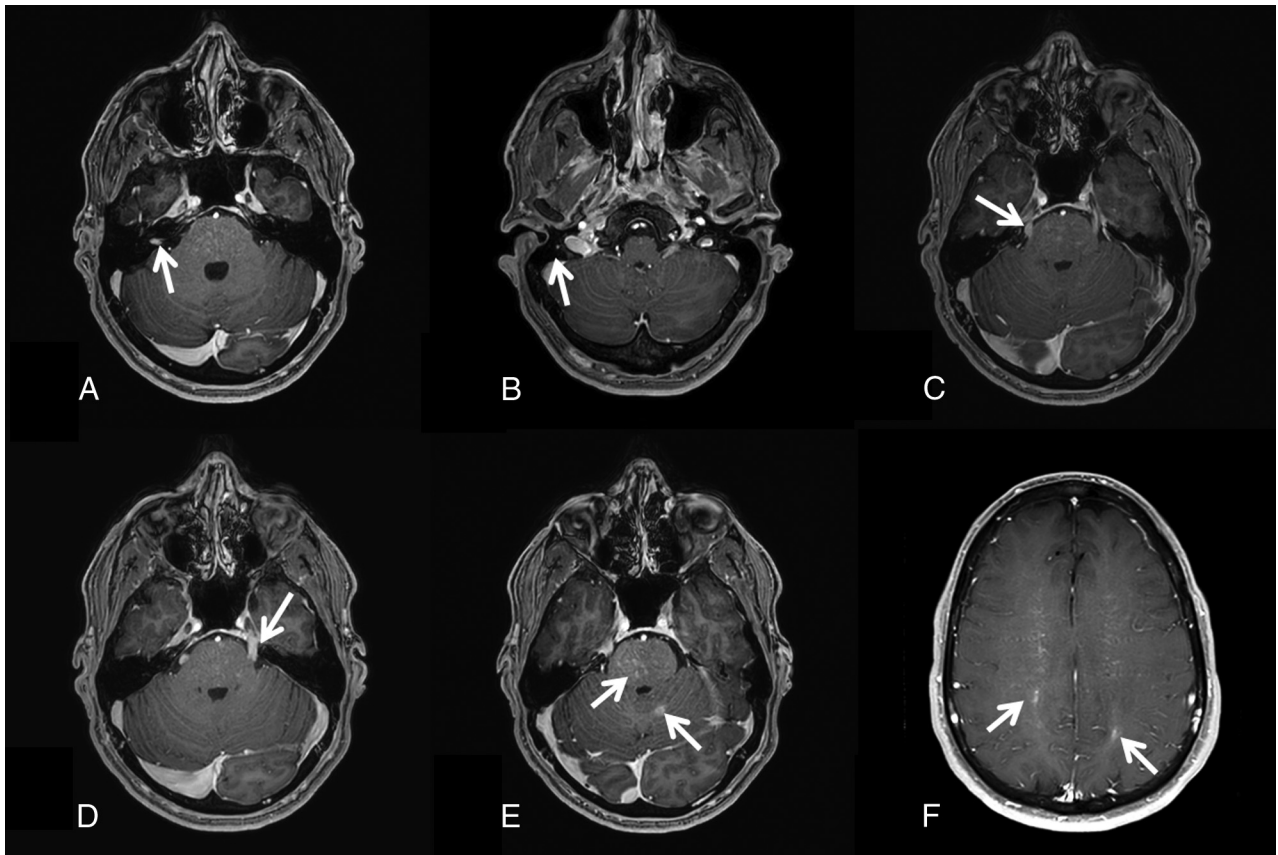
Postcontrast T1-weighted images demonstrate nodular enhancement involving the right facial nerve in the meatal (A) and mastoid (B) segments and the bilateral trigeminal nerves (C and D). Leptomeningeal enhancement along the cerebellar surface (E) and abnormal enhancement along the perivascular spaces in the pons and cerebral hemispheres (E and F) are also seen.
